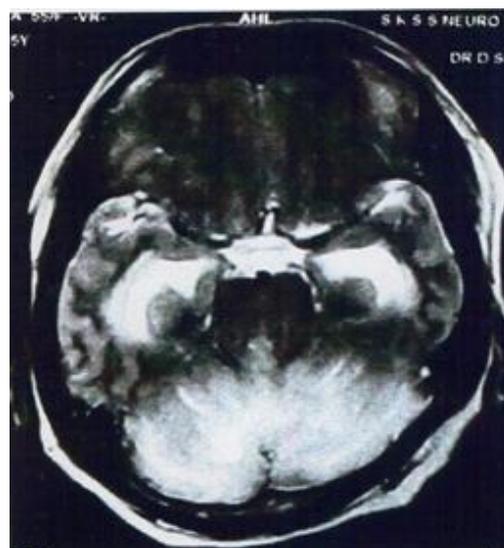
FLAIR Sequence - Bilateral Cerebellar Involvement
